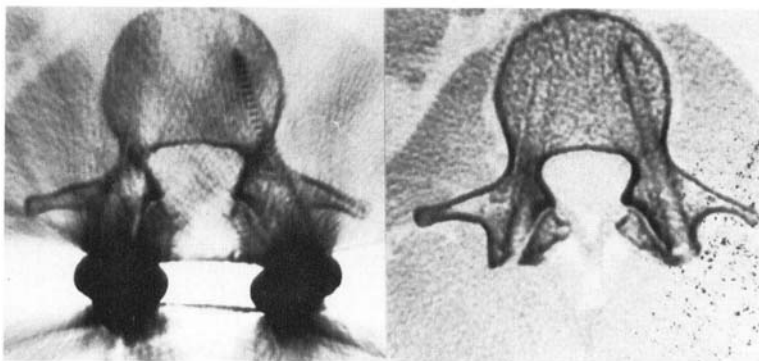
Apparently incorrect screw placement. CT after screw insertion (left) and after implant removal (right). Note also that, on the opposite side, an articular facet was damaged by the screw.
